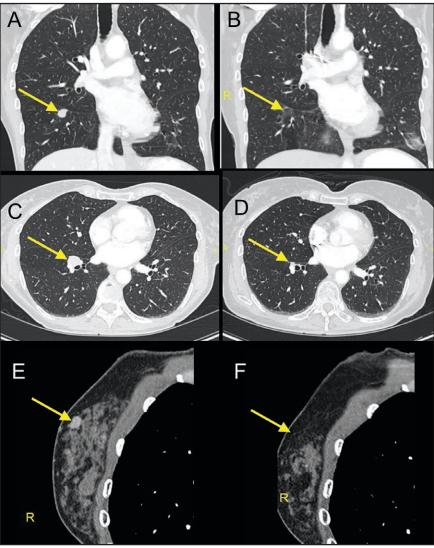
Computed tomography images depicting right interlobar lung and right chest wall softtissue masses from scans prior to radiation (A, C, E) with interval resolution 7 months later (B, D, F).
